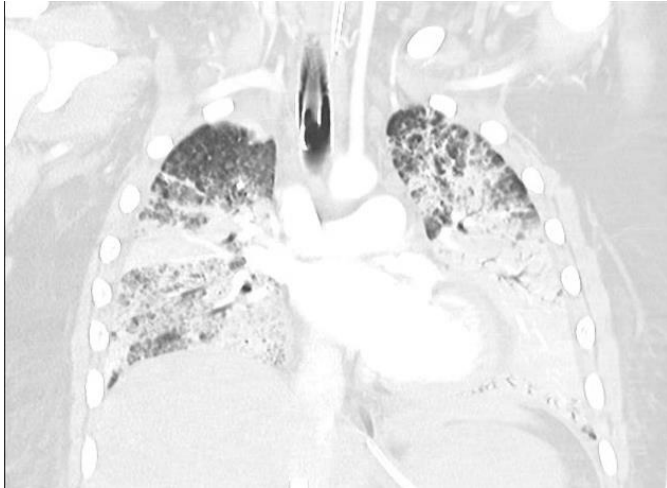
Coronal CT in GS patient showing widespread lung consolidation and ground glass pattern with the rest of the lungs, a finding indicating alveolar obliteration. (Case courtesy of Bruno Di Muzio, Radiopaedia.org, rID: 61650)
